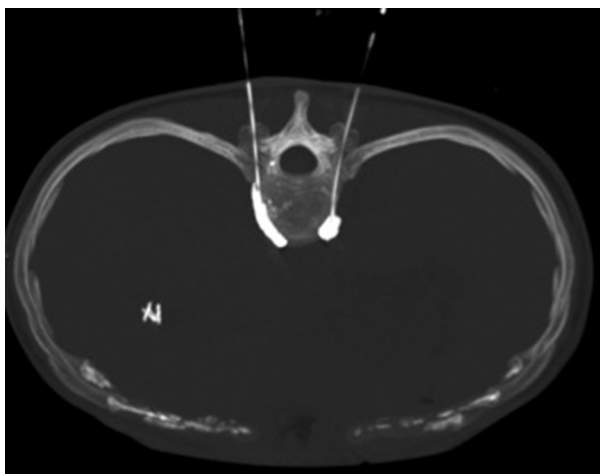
A maximum intensity projection of a computed tomography volume demonstrating the needles in the retrocrural space from a posterior approach and the expected distribution of contrast during a splanchnic block
